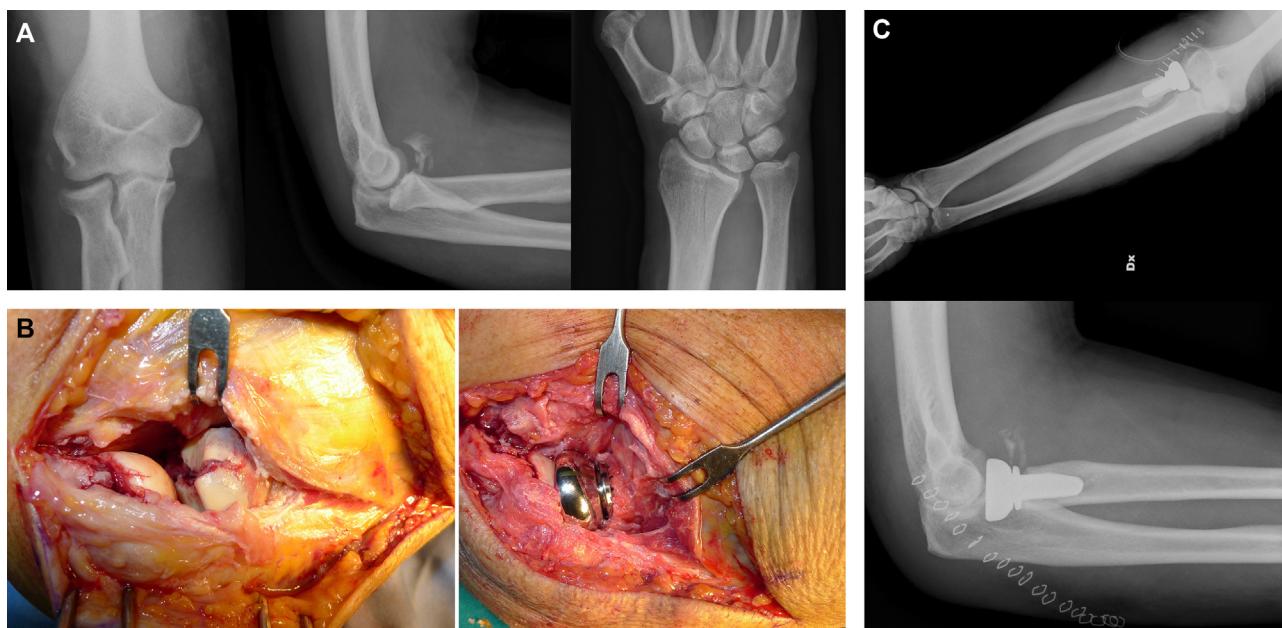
A. X-rays showing an Essex-Lopresti fracture-dislocation. B. Intraoperative view of a radial head fracture and radial head replacement. C. Postoperative X-rays showing the radial head replacement with anatomic implant and the presence of an anchor on the ulnar head, with restoration of the correct ulnar variance.
